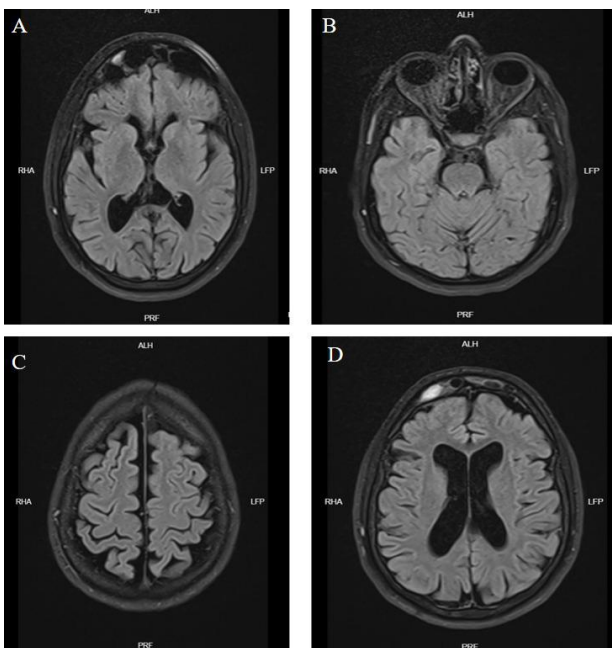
Normal post-treatment MRI demonstrating complete resolution of widespread hyperintense lesions previously observed in the posterior and cerebral regions, including the frontoparietal subarachnoid hemorrhage area, consistent with recovery from subarachnoid hemorrhage and posterior reversible encephalopathy syndrome (PRES)
